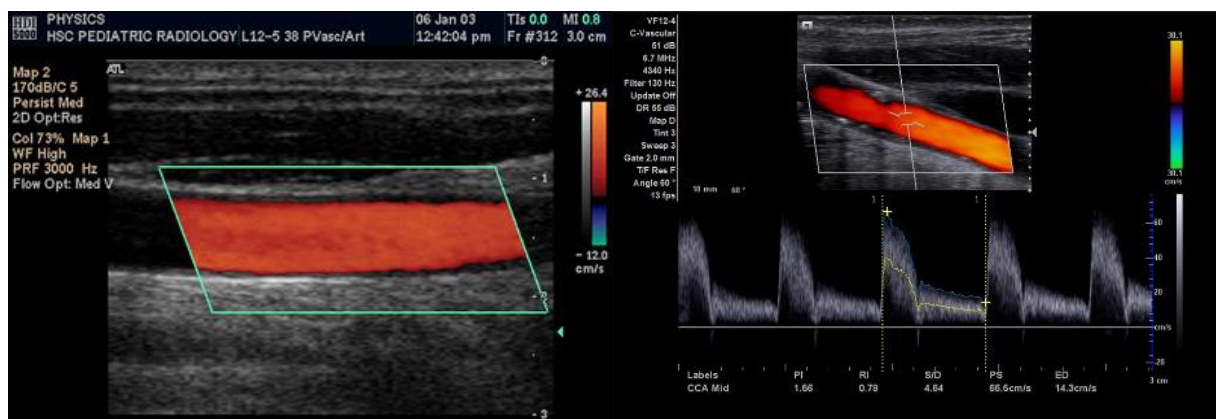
Spectral Doppler scan and Colour Doppler scan of the carotid artery. (152)
